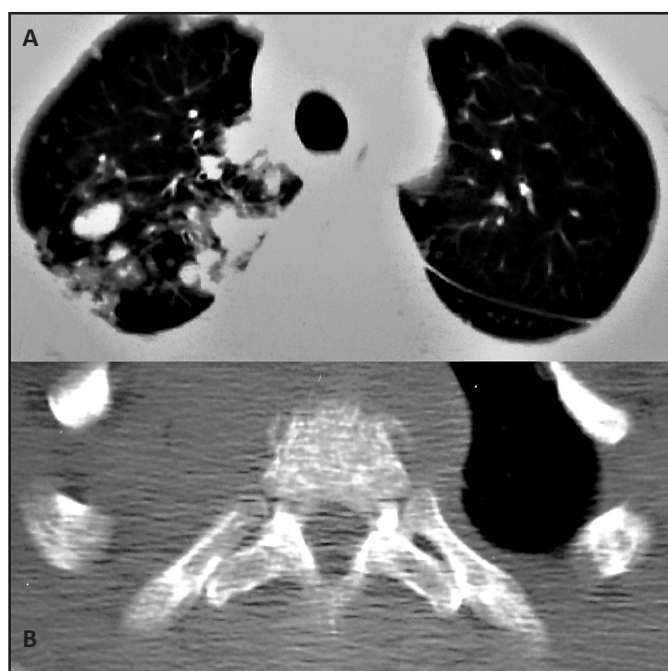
Computed tomography scan. In the lung window (A), there is an evident infiltrative mass on the right lung apex. In the mediastinal window (B), the mass can be seen infiltrating the vertebral body of a thoracic vertebra.
